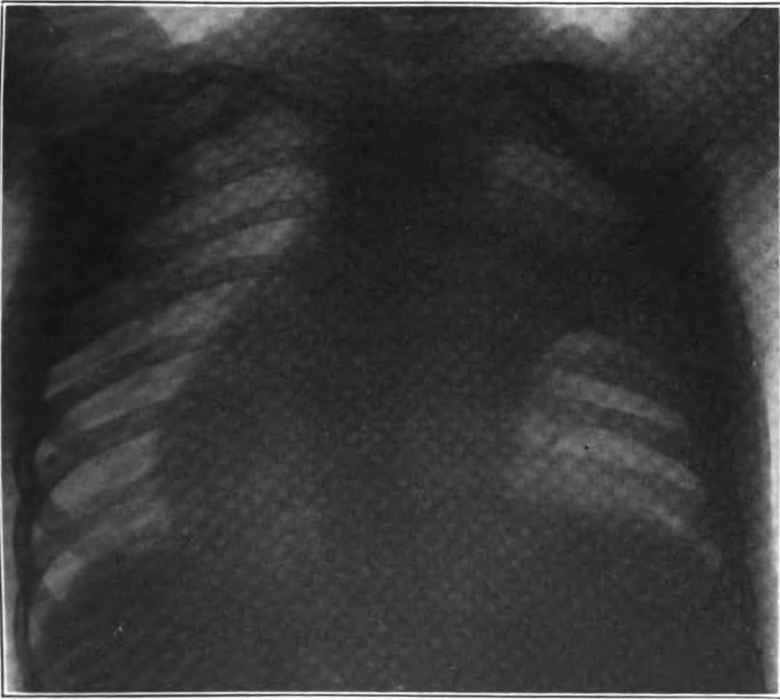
(Case 1). Radiograph taken May 8, 1915. Recurrence of hilus infiltration as in Figure 1, sharply limited below by the interlobar fissure.
